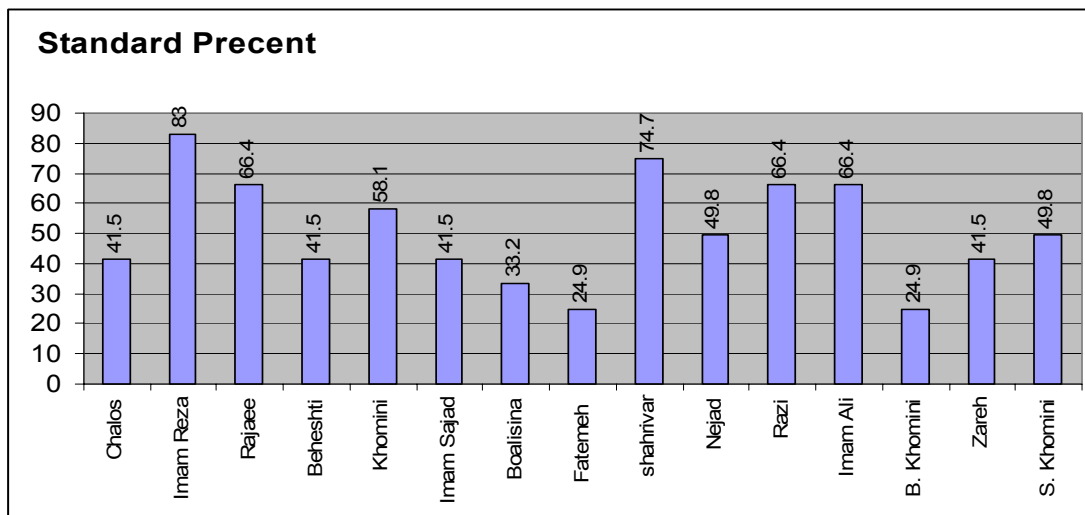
condition of dosimeter and protection of staff in the radiographic units, considering the parameter under study.
